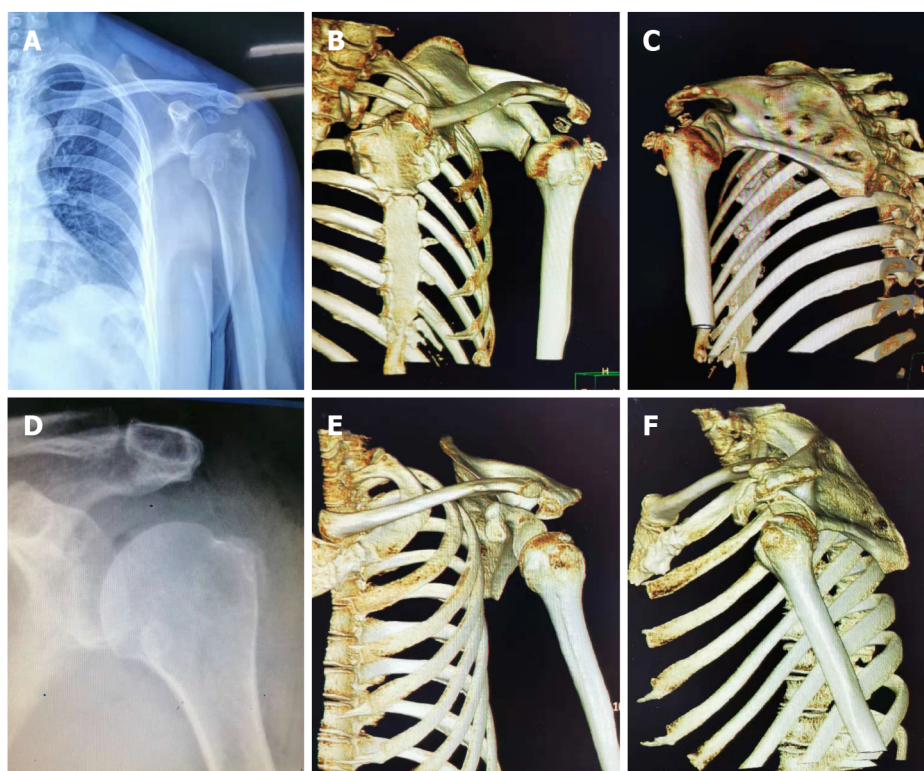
Imaging examinations of case two. A–C: Plain radiographs and three-dimensional computed tomography (3D-CT) reconstruction of the left shoulder, showing multiple intra-articular loose bodies and the subluxation of the humeral head; D–F: Postoperative radiographic re-examination and 3D-CT reconstruction showed no loose bodies in the subacromial space. The humeral head returned to a normal anatomical relationship.
